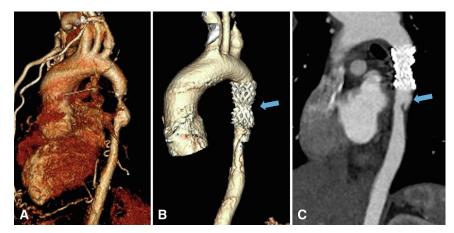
An adult patient with MAS with a supravisceral lesion (A) was admitted and received CP covered-stent implantation. Postoperative 4-month follow-up CTA showed stent-induced distal aortic tear (B and C; *blue arrow*). *MAS*, Midaortic syndrome; *CTA*, computed tomography angiography.
